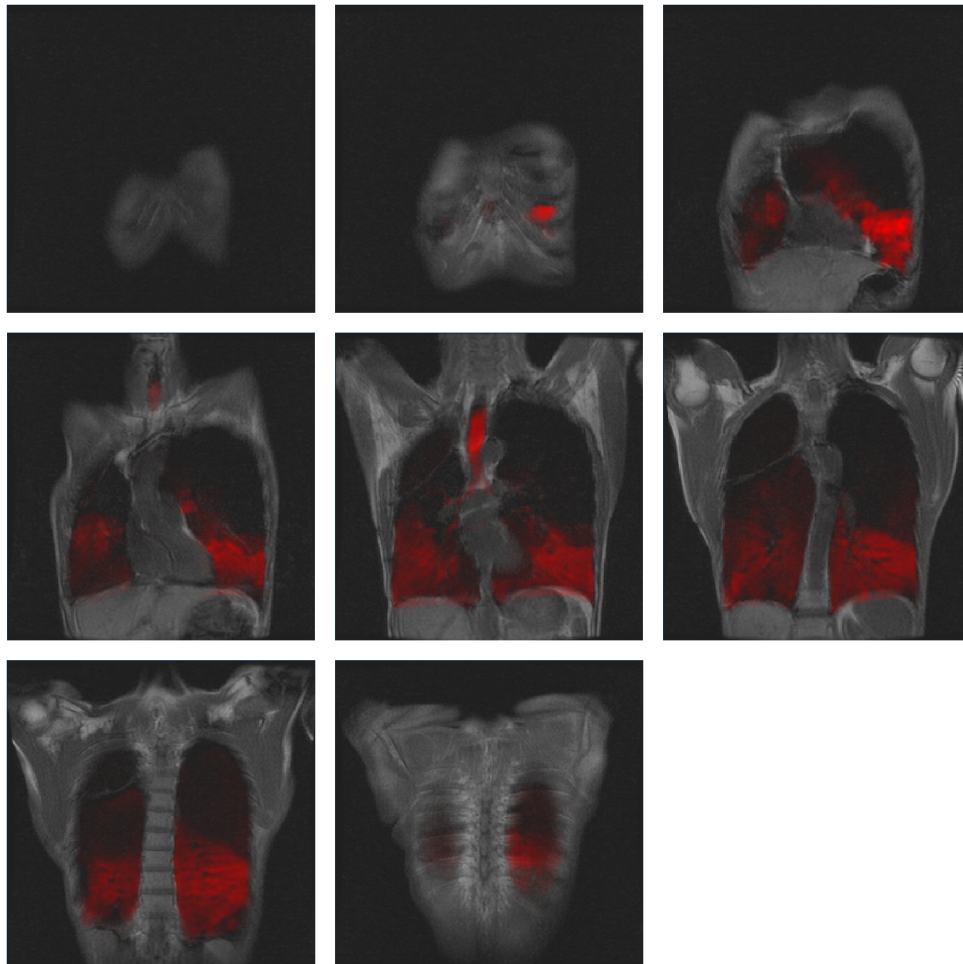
Coronal co-registered HP ¹²⁹Xe-MR ventilation imaging (red) and proton MRI from OXF0069. Co-registration to proton MRI enables the lung boundaries to be defined which is particularly important in the upper lobes where large HP ¹²⁹Xe-MR ventilation defects are present.
